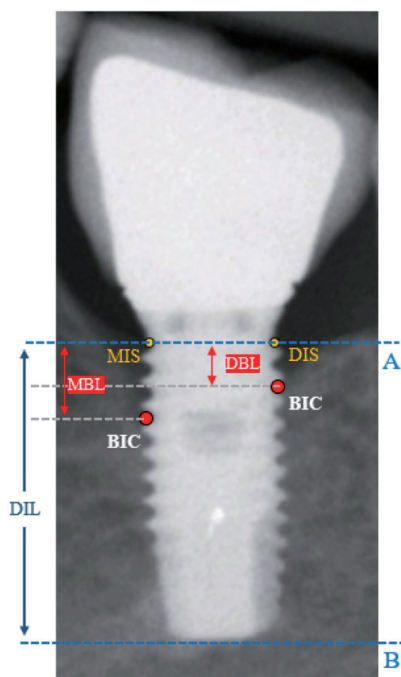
Radiographic analysis applied on bone level implants.
